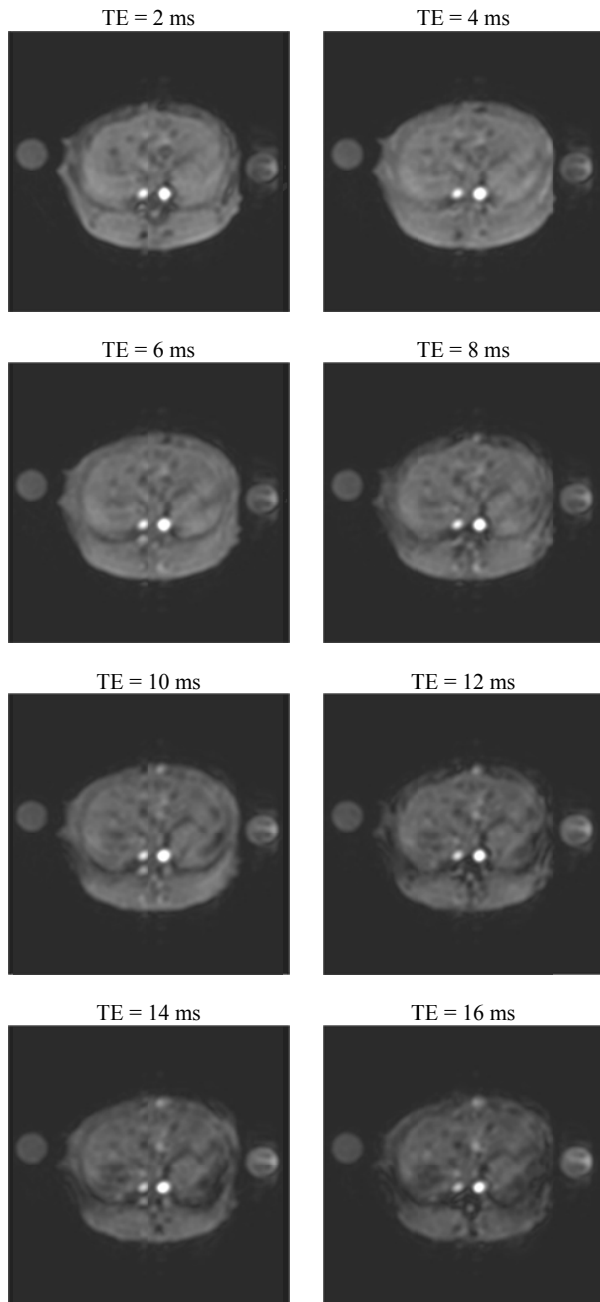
MRI liver images with different TEs
